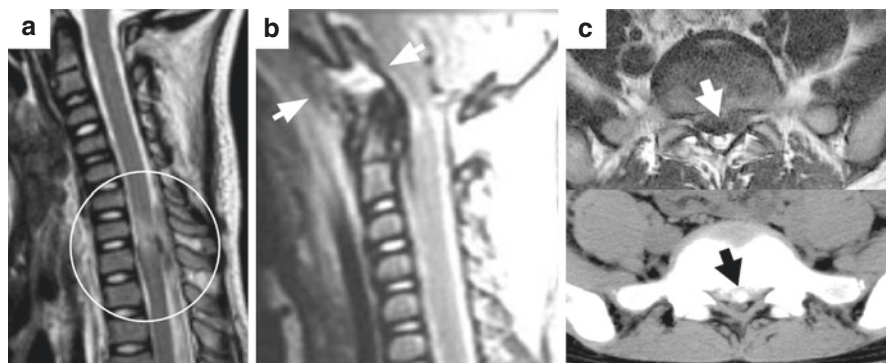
Radiologic examples SCIs in children. (a) MRI of SCIWORA (circled). (b) MRI of atlanto occipital dislocation (arrows). (c) Top (MRI) and bottom (CT) of vertebral apophyseal fracture at L5/S1 (arrow)
